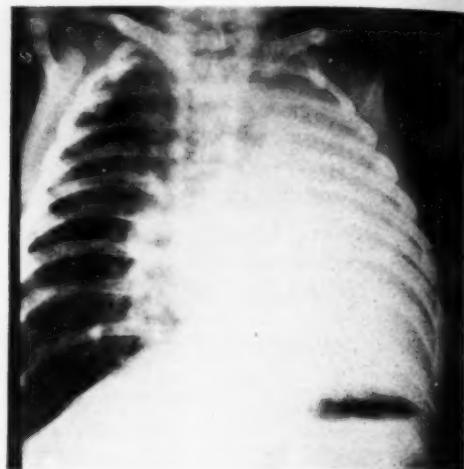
Case III. Roentgenogram at five months of age, showing massive atelectasis of the left lung.
